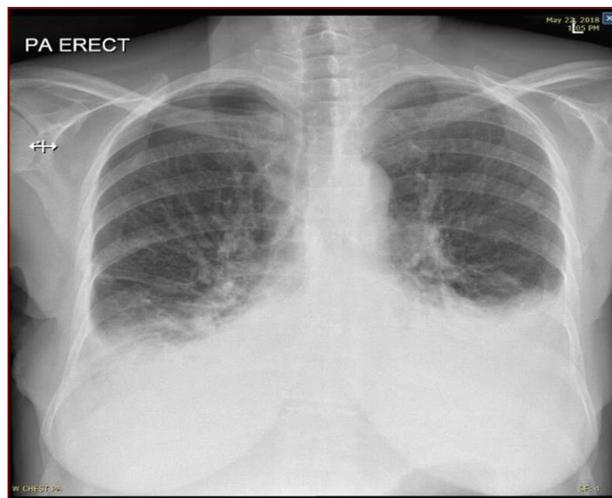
Chest X-ray showing collapsed consolidation at left lung base with bilateral pleural effusion.
